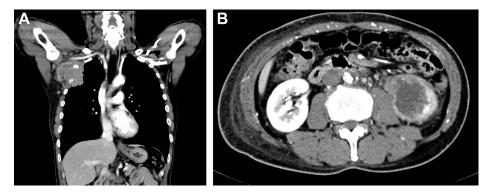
Chest computed tomography (CT) scan revealed a large mass with a cavity occupying the right upper lung field (A). Abdominal CT showed a mass in the inferior pole of left kidney and enlarged abdominal para-aortic lymph nodes (B).
